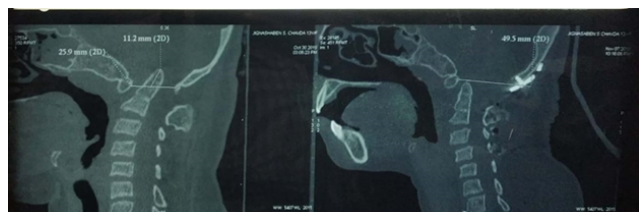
Pre op CT scan (Left side), Post op CT scan(Right side)
